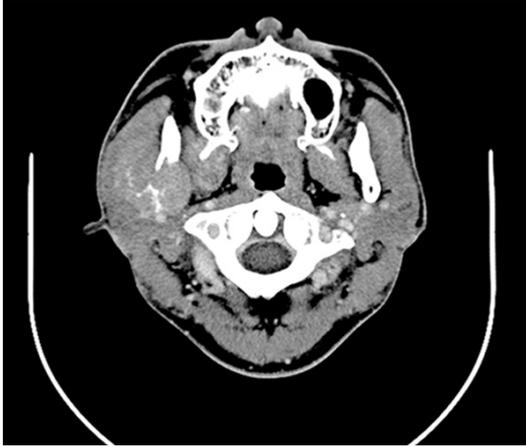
Computed tomography scan revealing bone destruction in the medullary and cortical portions of the right mandible.
